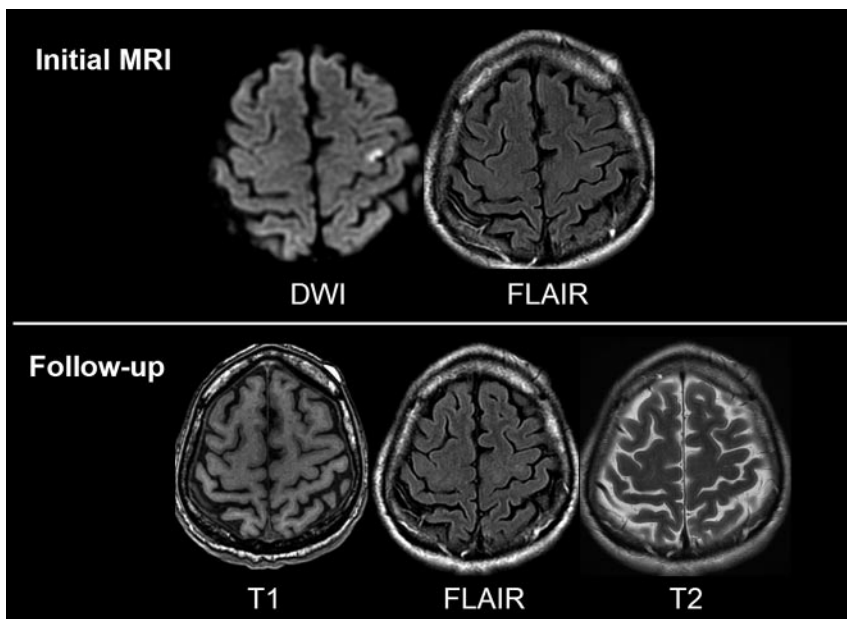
A 55-year-old man with sensory-motor deficit of the upper right limb for 90 minutes. Initial MR imaging (10 hours after onset) demonstrates a focal DWI hyperintensity with mild FLAIR signal intensity changes in the left primary motor cortex, matching clinical symptoms. On follow-up MR imaging (8 months after onset), no permanent injury can be identified.
